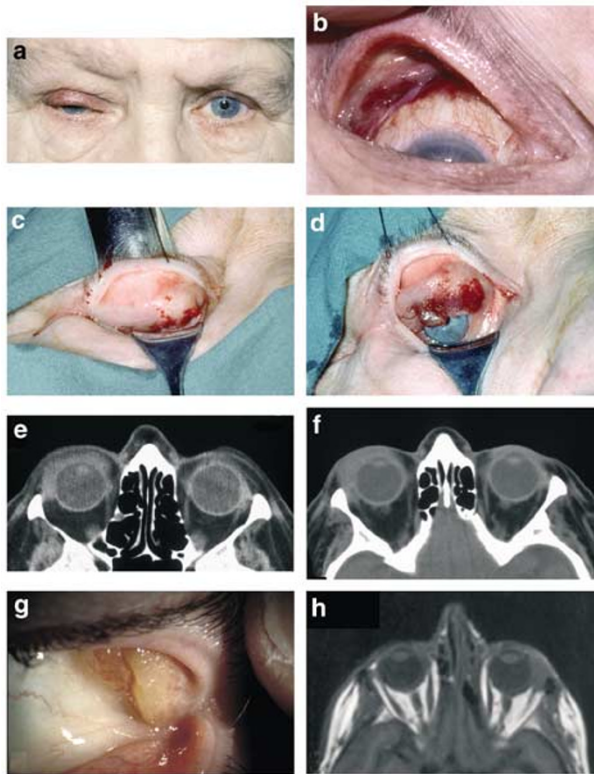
Patient-1. (a) Right-sided ptosis. (b) Orbital mass prolapsing through the right upper fornix. (c) and (d) Intraoperative photographs at the time of biopsy. (e) First CT orbits showing the right-sided orbital mass. (f) Repeat CT in 2002 showing the mass to be unchanged. Patient-2. (g). Translucent, yellow, and nodular orbital mass prolapsing through the left upper fornix. (h) MRI of orbits showing the mass in the left orbit.
